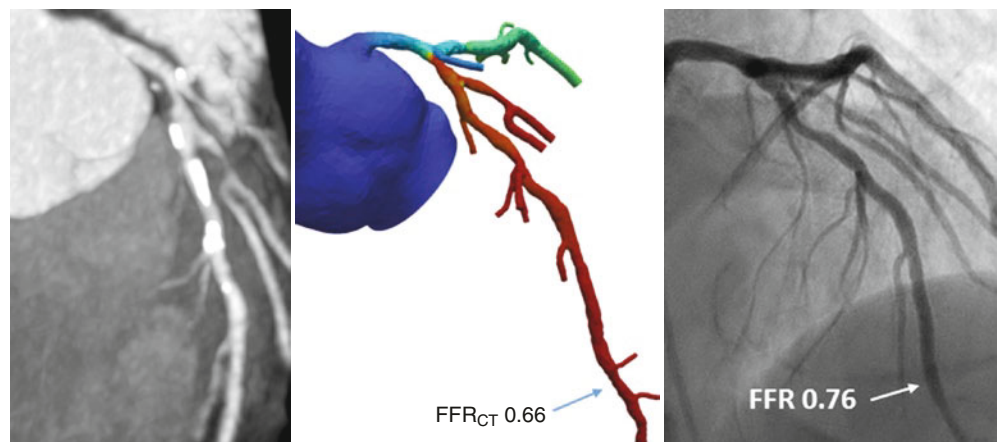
One potential use of  $FFR_{CT}$  is to defer invasive coronary angiography that is likely to find nonobstructive coronary artery disease. This  $FFR_{CT}$  comes from a patient in the PLATFORM trial [7], which demonstrated that 61% of scheduled invasive coronary angiograms were cancelled in patients with  $FFR_{CT}$  without any clinical consequences
